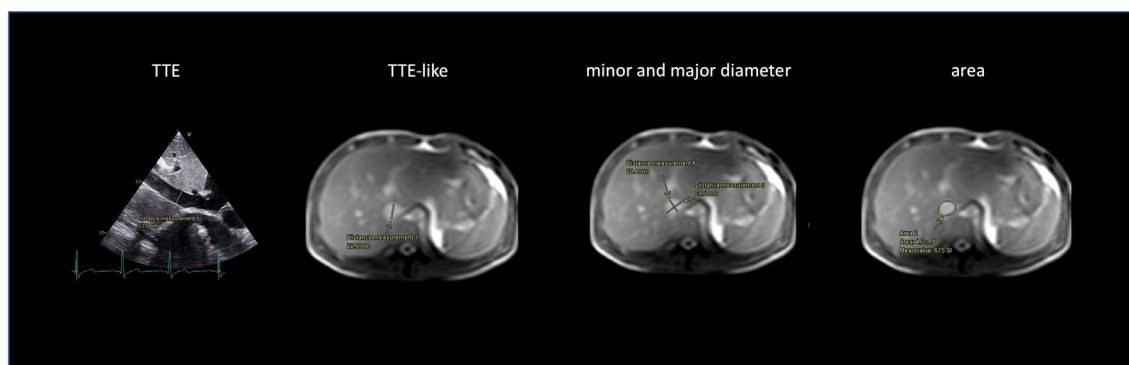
Comparison of IVC measurements. On the left is shown the expiratory IVC at TTE in longitudinal direction. The IVC diameter at TTE was measured 1–2 cm below the confluence with the hepatic veins (left). For analysis of the IVC at MRI, we used different strategies, i.e., using a TTE-like orientation (middle left), measuring the minor and major IVC diameters (middle right), and contouring the IVC area (right). Measurements were performed at expiration and inspiration.
